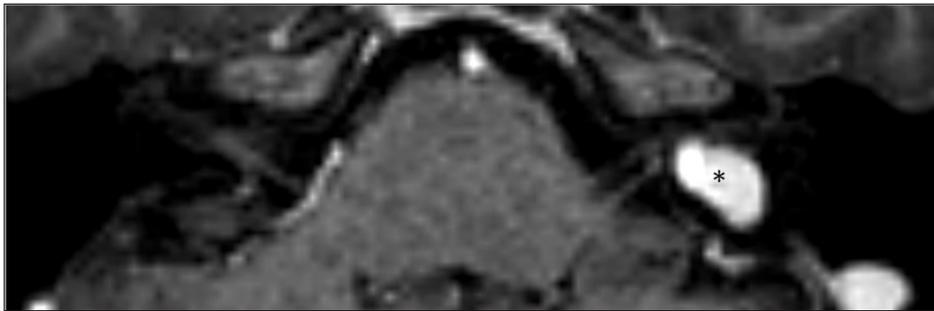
Axial hi-resolution Gd-enhanced T1-weighted sequence (T1W-3D TFE Gd) at the level of the internal auditory canal showing smooth, vivid enhancement of a high-riding jugular bulb (black asterisk), connected with the sigmoid sinus in lower cuts
